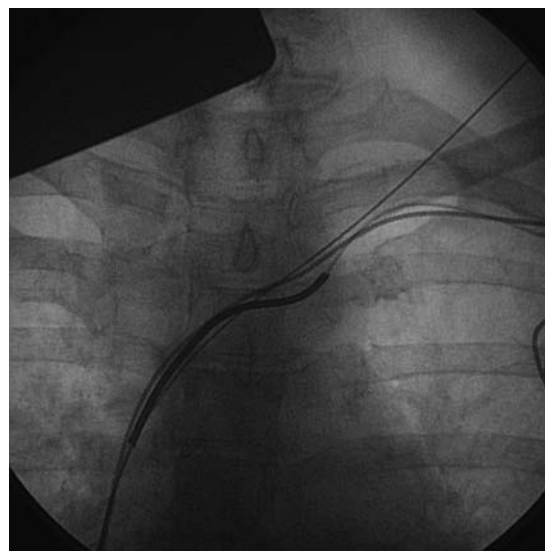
Intraoperative chest radiograph (Patient 3). A 0.38 in. guidewire is inserted into the venous bed under fluoroscopic vision in the right atrium and the needle is withdrawn.
